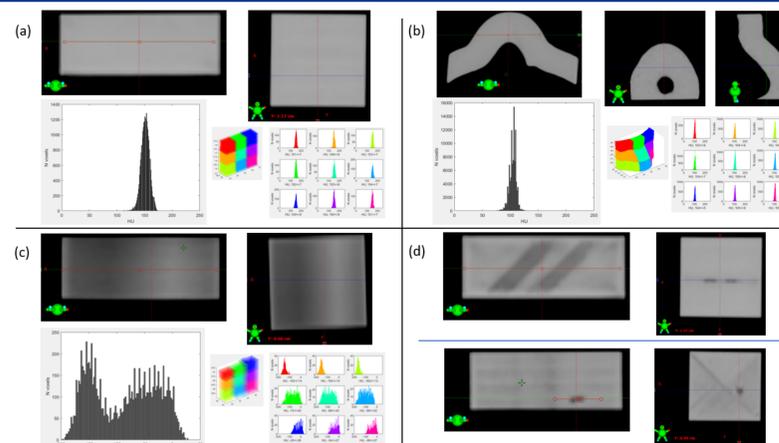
Example CT images (Eclipse, Varian Medical Systems, Palo Alto, CA) +/- analysis of samples with: $\sigma_{HU\ overall} \leq 10$ HU: standard (a) and clinical (nose) geometry (b), vs. sample with $\sigma_{HU\ overall} > 10$ HU = fails uniformity criterion (c) and 2 sample failed (FDM) prints (d). The CT image display for (c) is W/L = 350/0 HU, for all others a soft tissue W/L is used (W/L = 350/50 HU).
